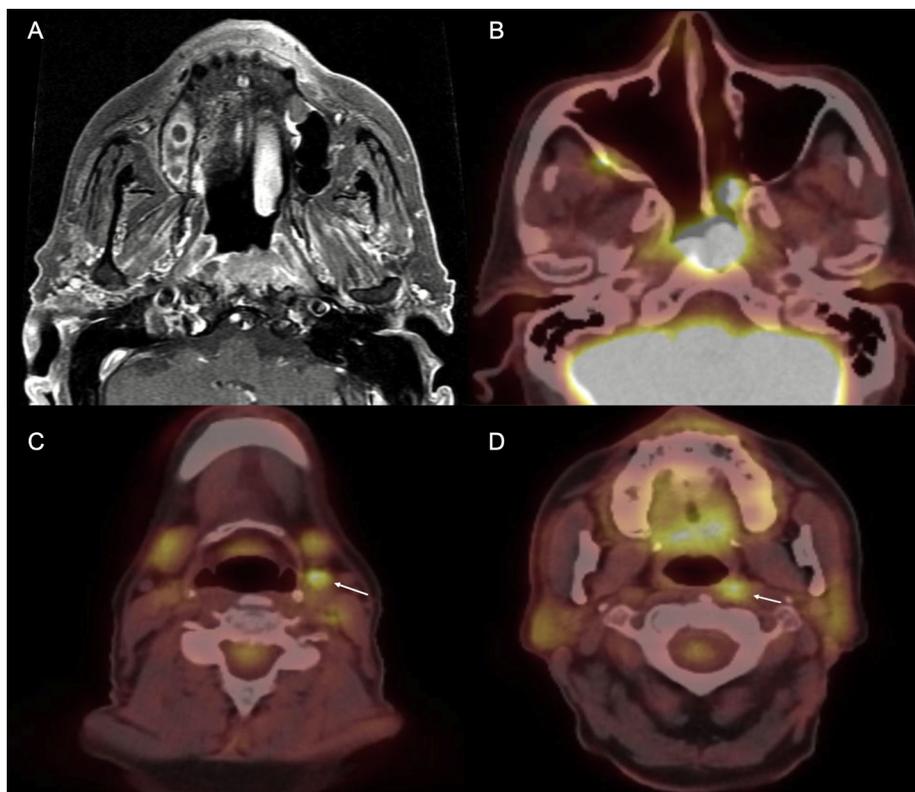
Findings on Imaging. Contrasted axial T1 MRI (A) and axial PET/CT (B) demonstrating FDG-avid nasopharyngeal primary lesion with erosion into the clivus without intracranial extent. FDG-avid cervical (C, arrow) and retropharyngeal (D, arrow) demonstrating nodal metastatic disease.
